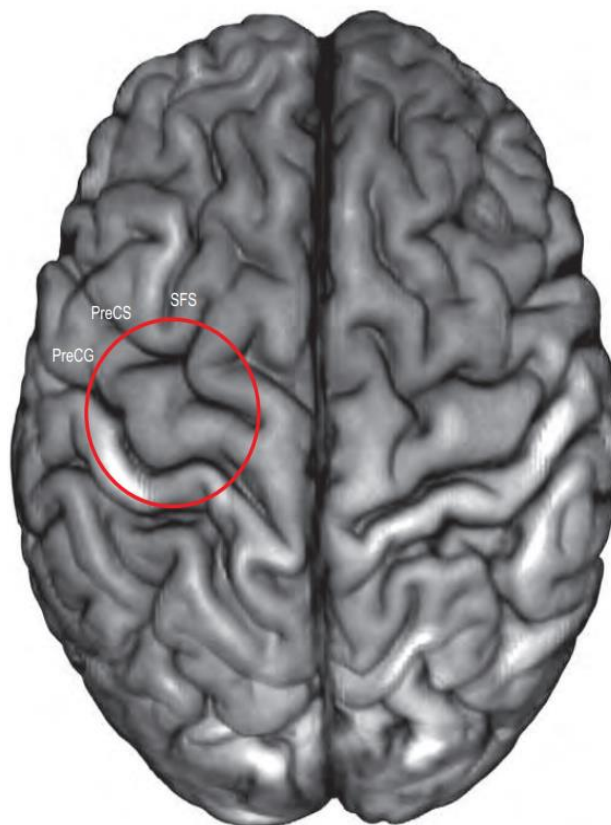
The hand motor activation site, corresponds to a knob-like cortical area of the contralateral precentral gyrus, which in MRI axial planes usually resembles an inverted omega shape (the area within the red circle) and may be identified by its relationship to the posterior end of the superior frontal sulcus. Abbreviations: PreCG, precentral gyrus; PreCS, precentral sulcus; SFS, superior frontal sulcus [13].
